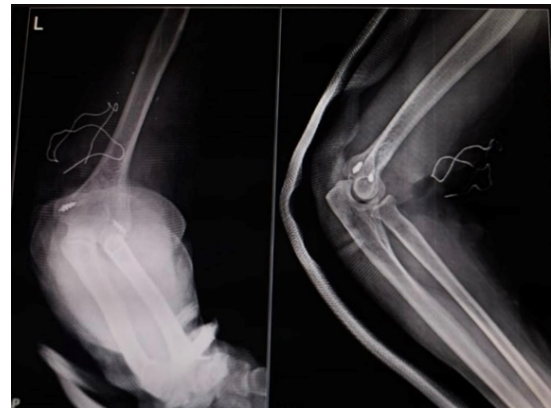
Immediate post of x-ray
